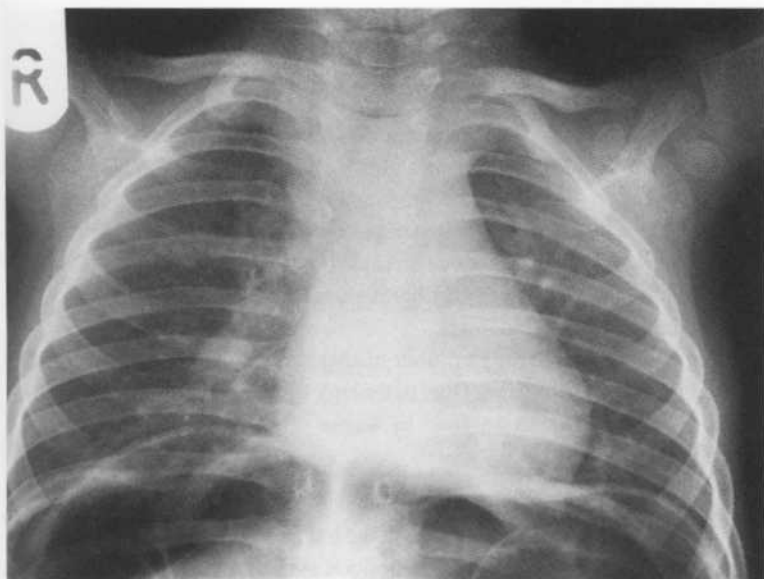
Child with meteorism This is the X-ray of a young child with a suspected chest infection who had been crying profusely before the film was taken.
